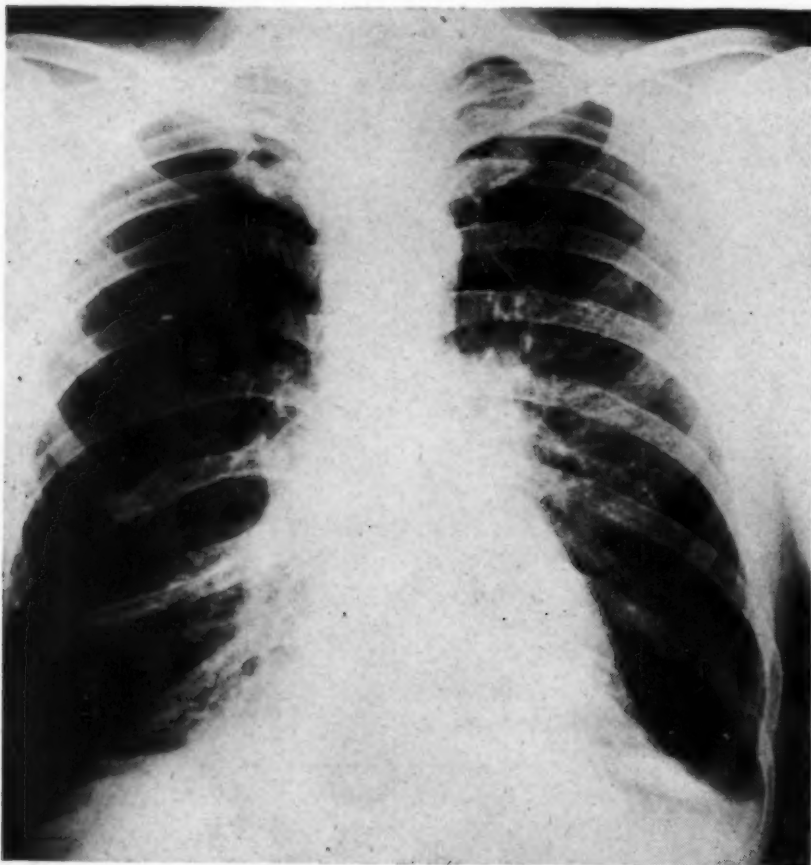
P. A. x-ray of chest following induction of artificial pneumothorax on the right side. Only a small pocket of air is seen laterally at the base. (Note: This film was retouched slightly to bring out the margin of this space.) The wall of the cyst is seen bulging into the pleural air space.
